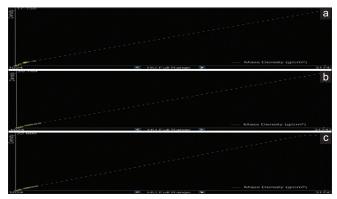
Variation of the extrapolated Hounsfield units-relative electron density calibration curve for Siemens, GE and Toshiba computed tomographies. (a) Siemens Somatom, (b) GE Optima, (c) Toshiba Aquilion
